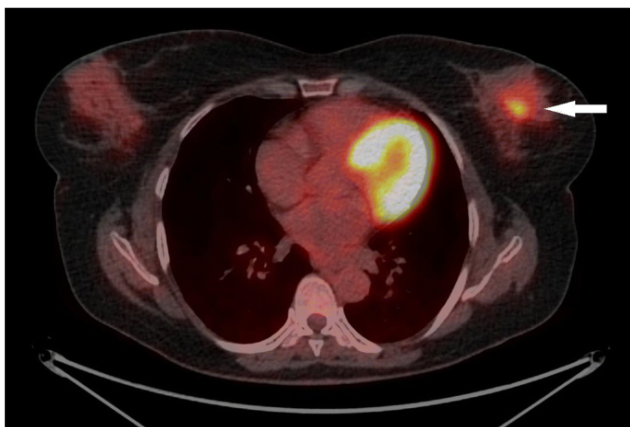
A breast cancer single nodule highlighted by Breast PET/CT.
